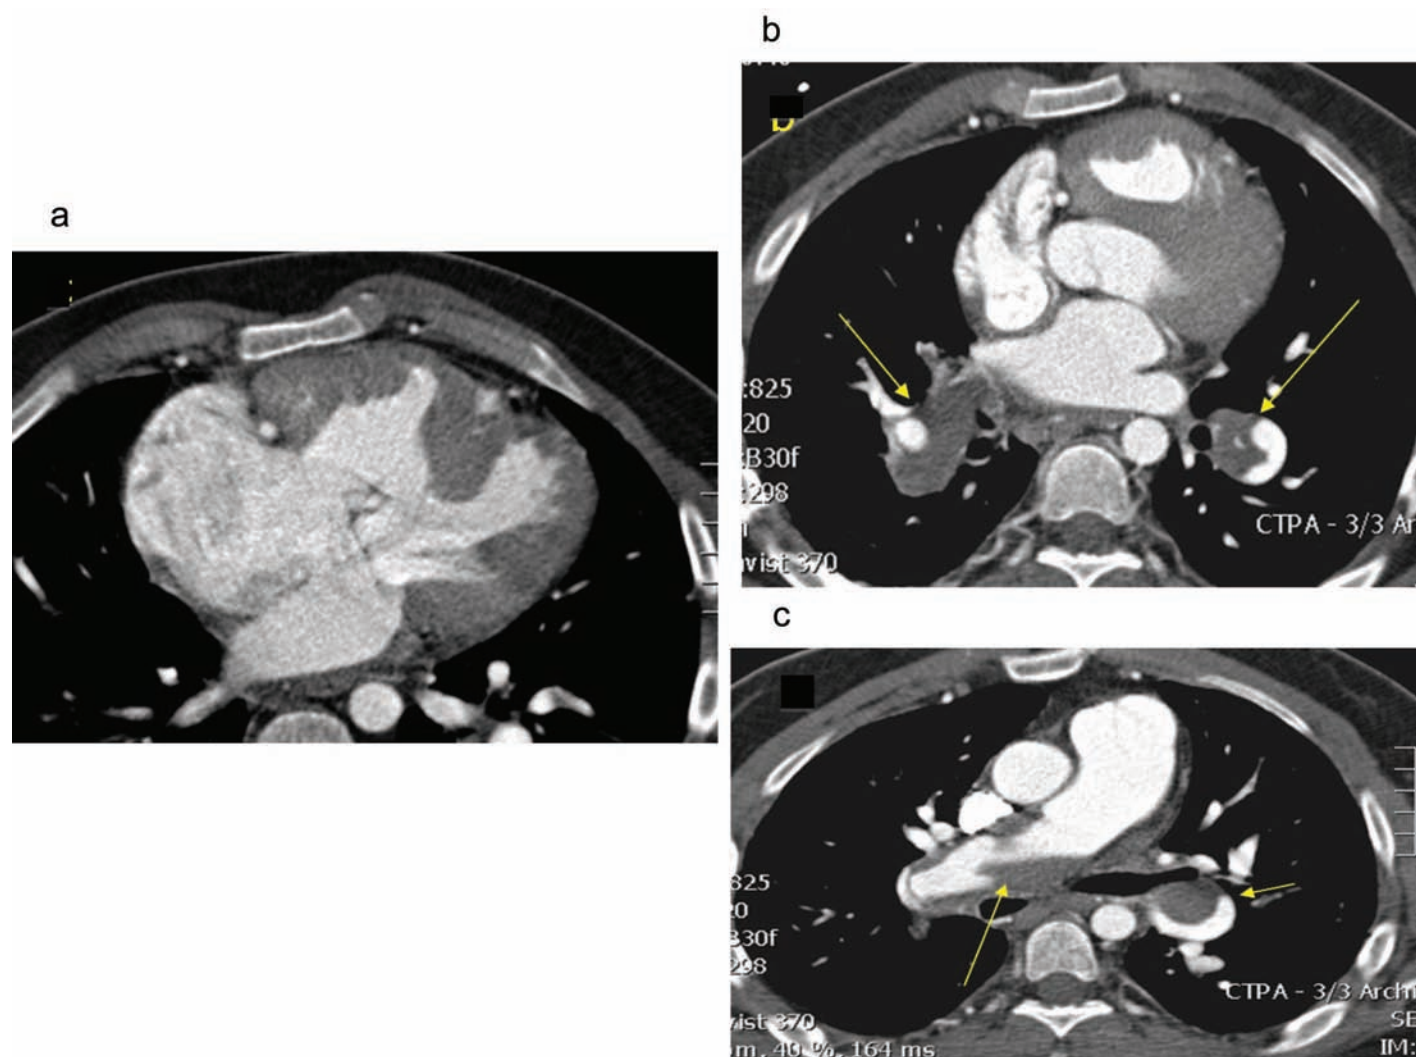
Computed tomography pulmonary angiograph of patient with AVSD and PAH. (a) The common AV valve and atrial and ventricular components of the AVSD are seen, the right atrium is dilated, and there is RV hypertrophy. (b) The main pulmonary artery is dilated and larger in cross-section than the ascending aorta. (b and c) Extensive thrombus is present in the branch pulmonary arteries (arrows).
